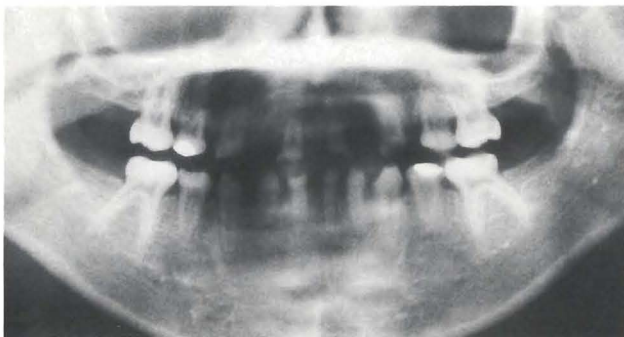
Orthopantomogram of the patient. Note that all permanent tooth buds are absent.
